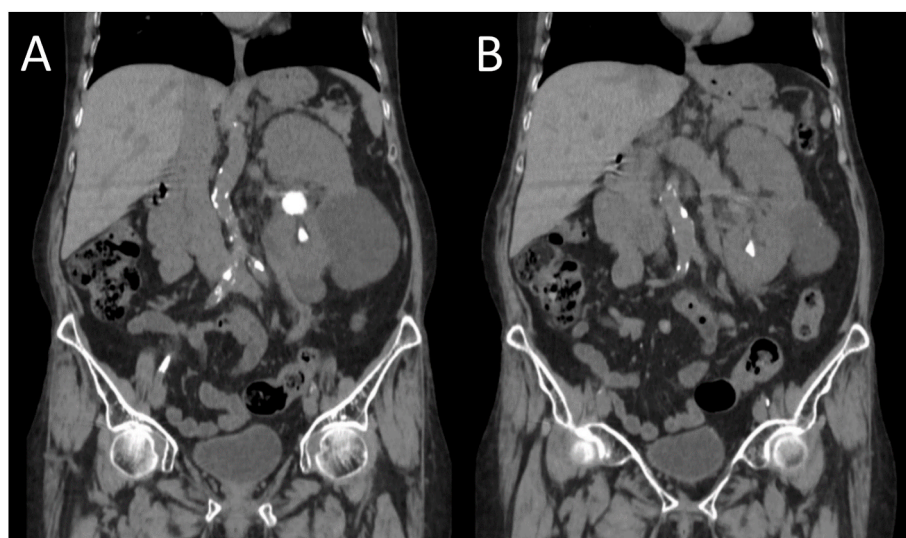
Abdominopelvic computed tomography (CT) scan showing the left kidney with a stone measuring approximately 20 × 11 mm in the middle pole and two other stones in the lower pole measuring up to approximately 13 × 7 mm.
